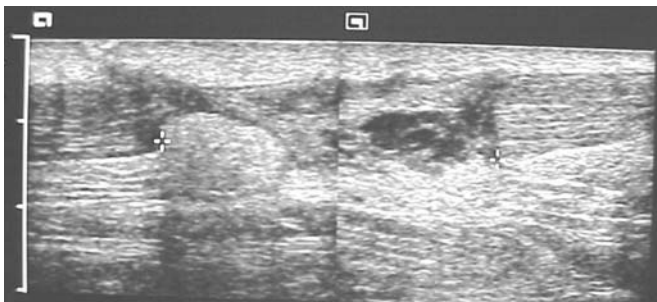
Sagittal plane ultrasound of the Achilles tendon following a laceration injury with distraction of the tendon ends to the asterisks, in an otherwise normal tendon.
